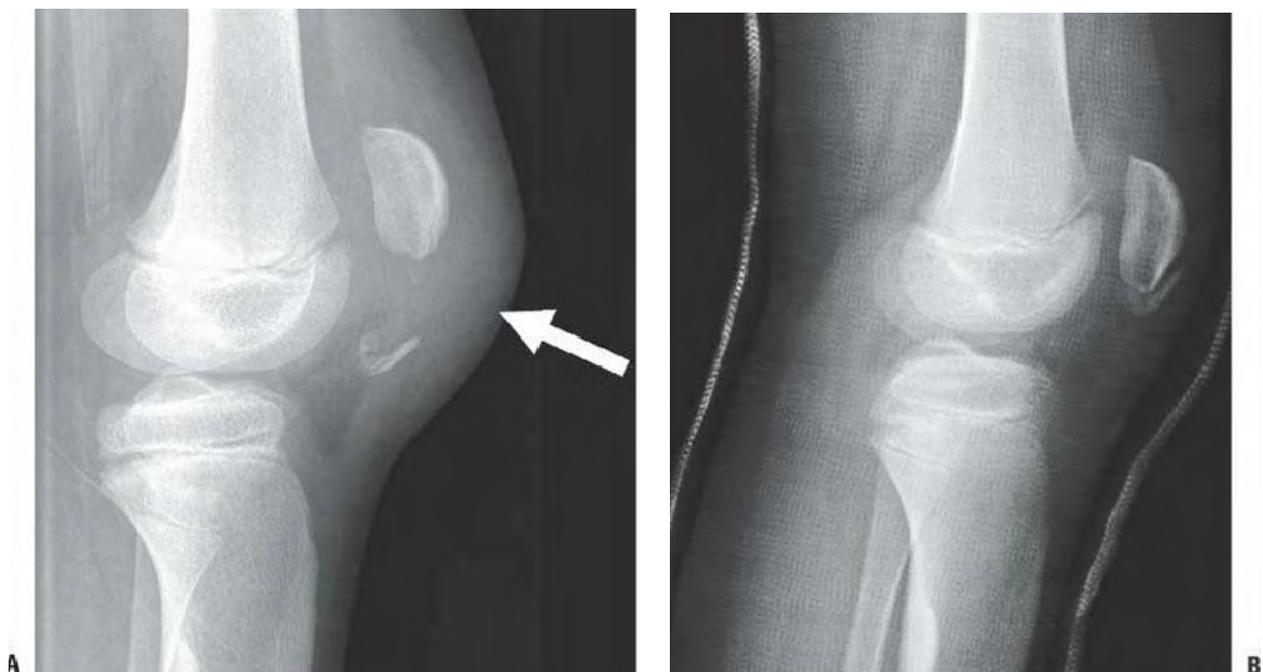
Preoperative (A) and immediate postoperative (B) lateral radiographs of a patellar sleeve fracture. Note the extreme soft-tissue swelling localized over the fracture site (*arrow*); this can be a valuable diagnostic sign in more subtle fractures.
